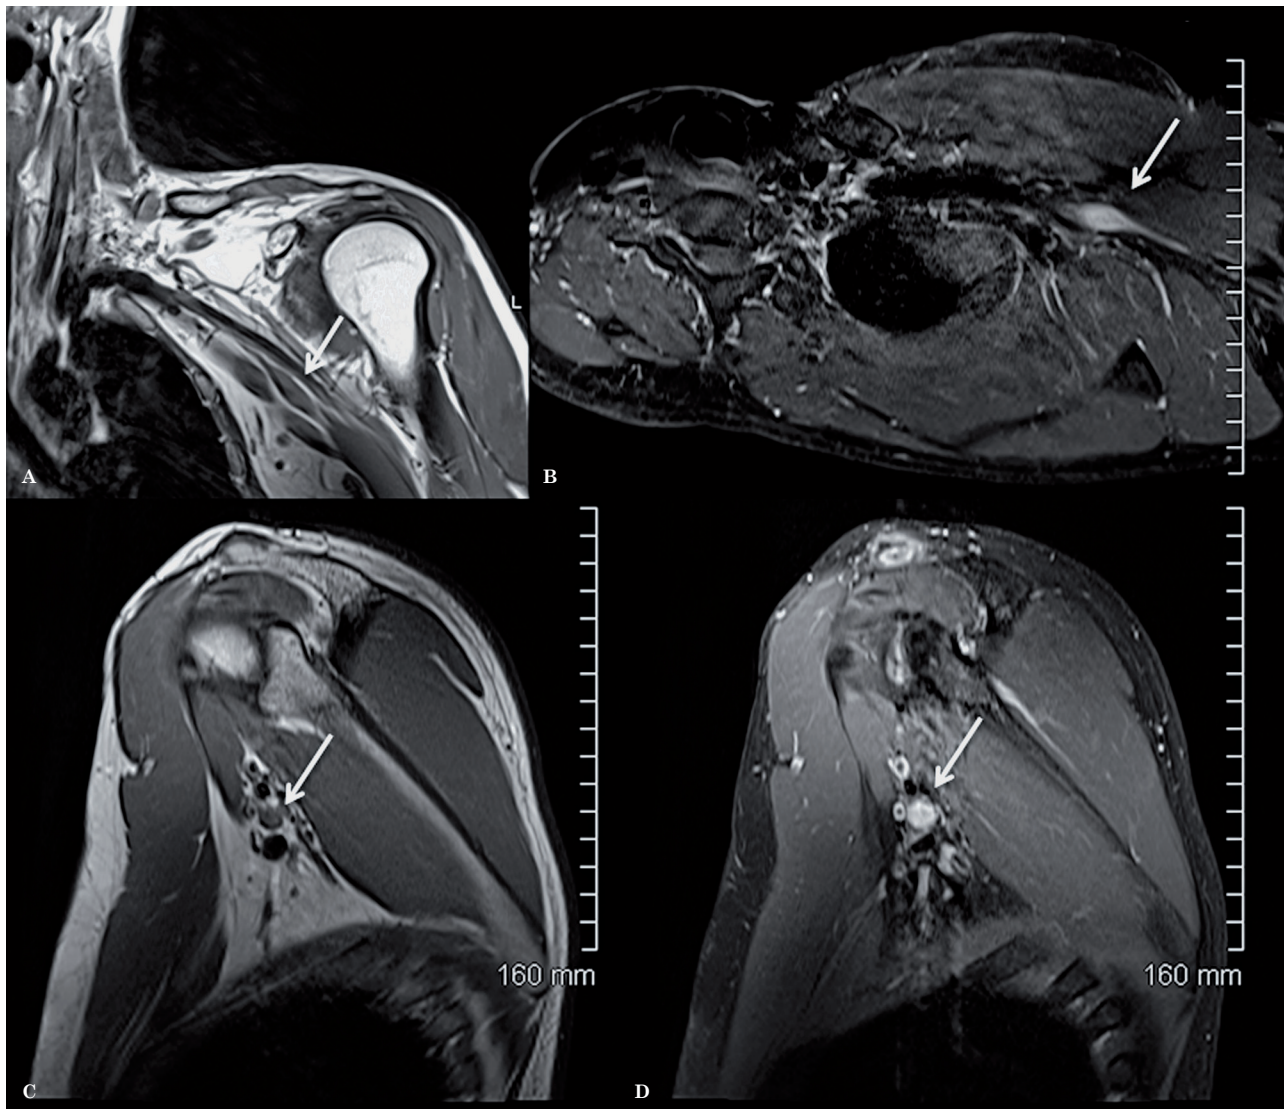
MRI of left brachial plexus using the modified technique, in 2011, as a follow up study for ulnar neuropathy. Coronal oblique T1 (A), axial oblique T1 post-contrast with fat saturation (B), sagittal T1 (C) and sagittal T1-weighted sequence post-contrast with fat saturation (D) show a focal well-defined enhancing mass lesion along the proximal branches of the left brachial plexus, likely consistent with a schwannoma.
